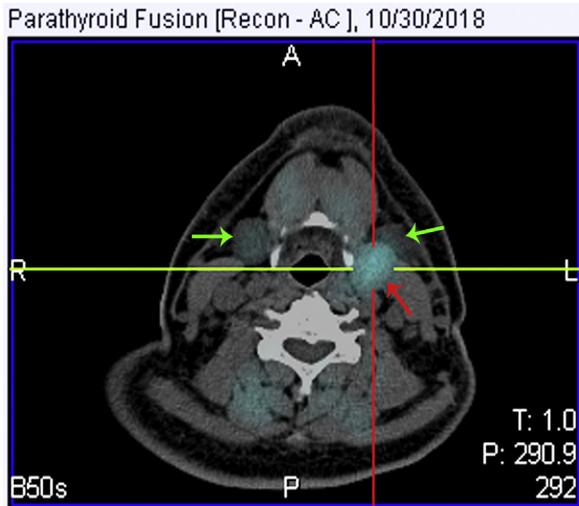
Preoperative radiographic assessment of ectopic parathyroid adenoma. The fused  $^{99m}\text{Tc}$ -MIBI and SPECT-CT images show an accurate localisation of the mass on the medial-posterior aspect of the left submandibular gland. (the adenoma is shown by the red arrow and the submandibular gland is indicated by the green arrow).
